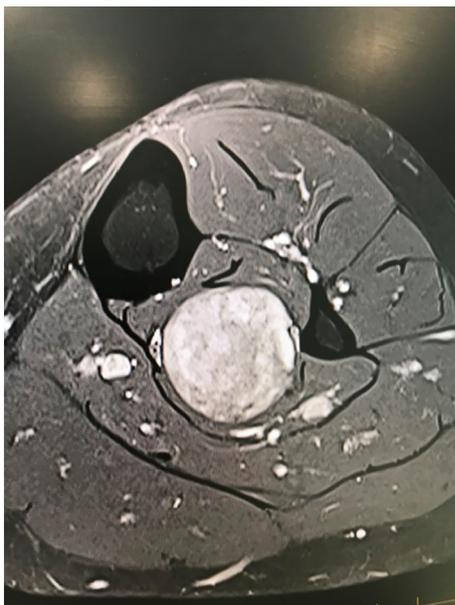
MRI appearance of a schwannoma of the tibial nerve, noting its relation to the nerve and well-formed capsule.
